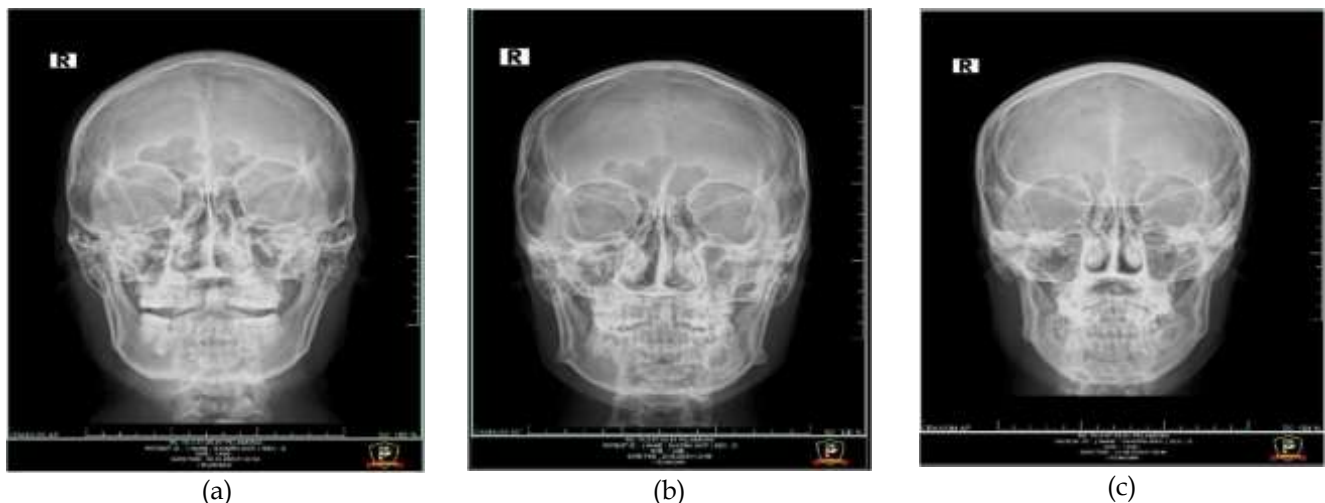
Cranium radiograph for volunteers: (a) 1 with 200 mA, (b) 2 with 250 mA, and (c) 3 with 320 mA
